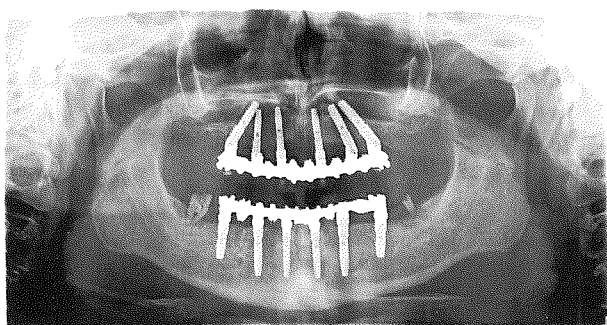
Radiograph performed 1 year after surgery.
